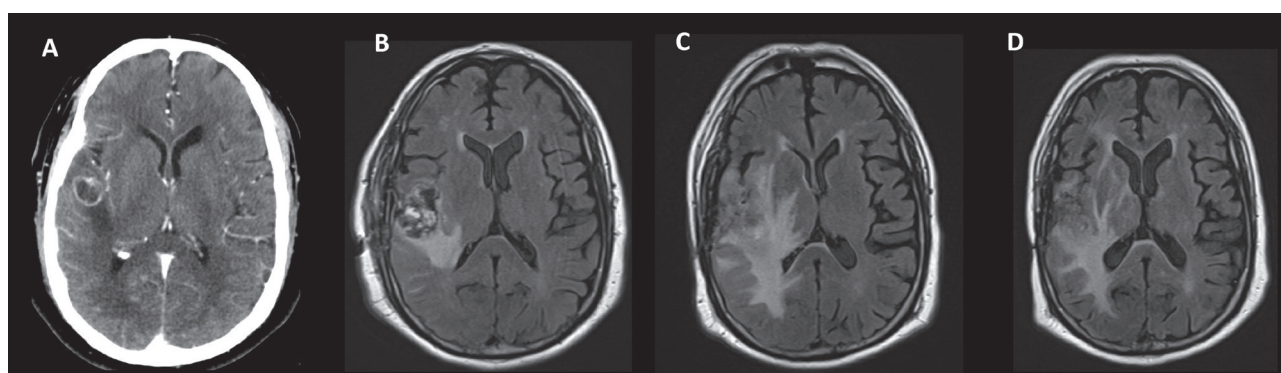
Serial brain scans over the described disease course. Initial contrasted CT head scan demonstrating right temporal lobe mass with concentric pattern of enhancement, later biopsied and confirmed to be consistent with glioblastoma (A). Brain MRI scan (T2/FLAIR sequence) with notable postoperative changes (B). Follow-up brain MRI (T2/FLAIR sequence) with interval increase in tumor size and associated edema (C). Repeat brain MRI (T2/FLAIR sequence) showed slight interval decrease in associated edema (D).
